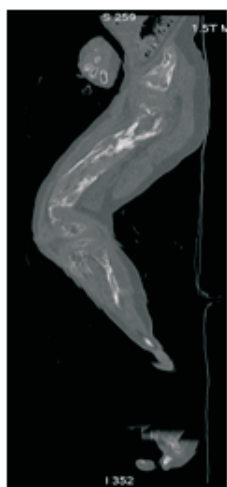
Sagittal CT image of left lower limb.
